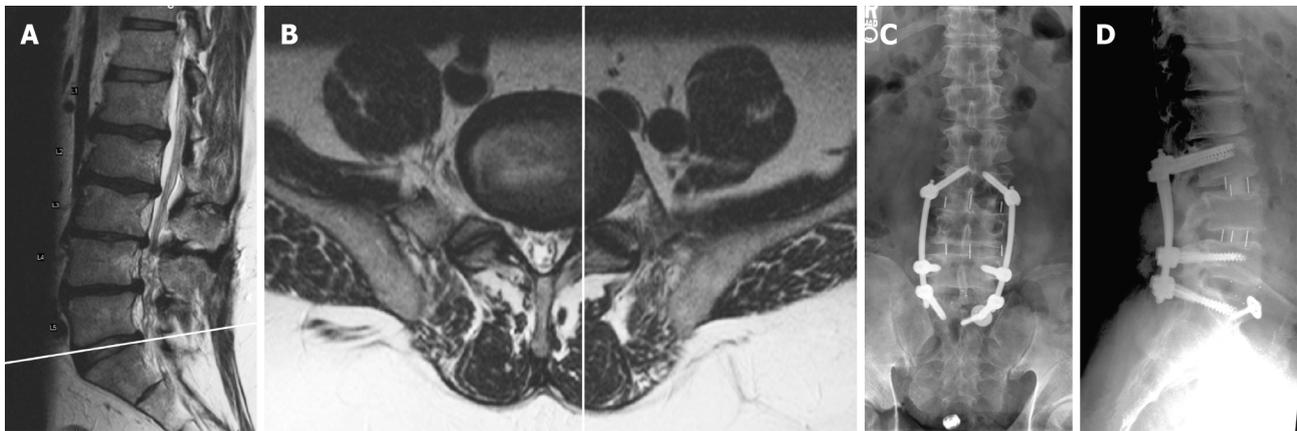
Preoperative magnetic resonance imaging sagittal (A) and axial (B) images and postoperative anteroposterior (C) and lateral (D) upright radiographs for Case 1. Image A shows the scout line corresponding to the axial image B. The anteroposterior *facet line* through the medial border of the left L5-S1 facet joint runs medial to the medial border of the left CIV (B). CIV: Common iliac vein.
